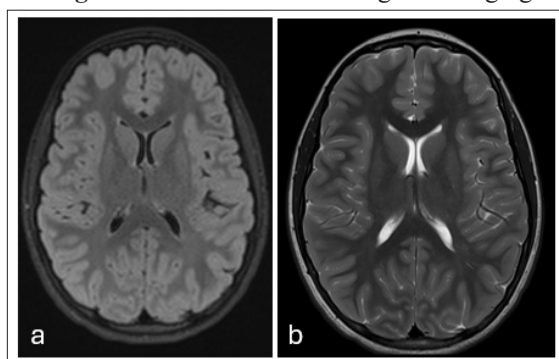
(a) Axial FLAIR and (b) Axial T2-Weighted Sequences
